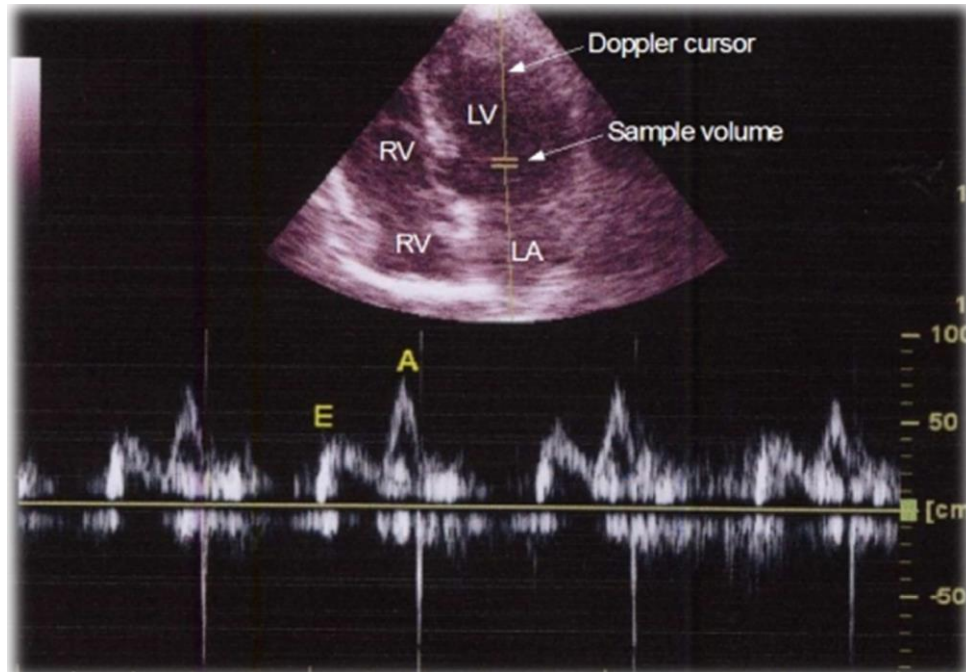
Doppler ECHO: Measurement of E velocity and A velocity
